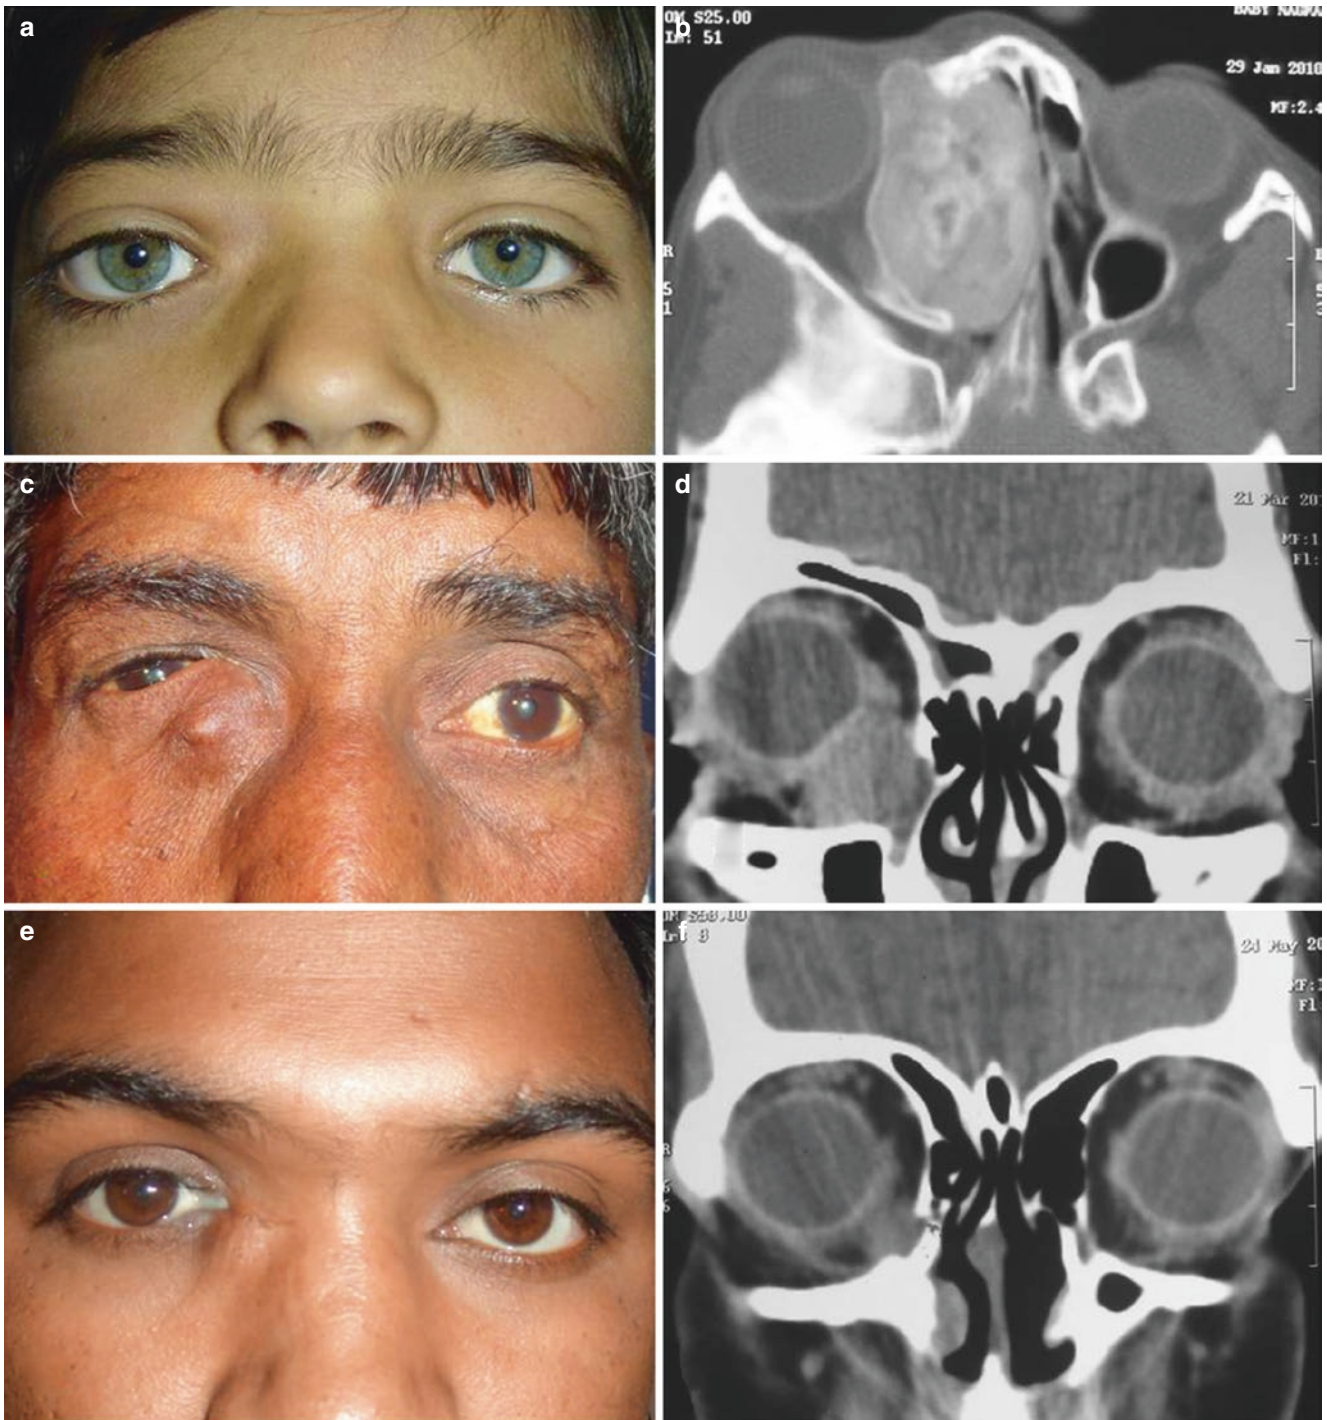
Imaging findings in patients with epiphora. Young child with unilateral telecanthus complaining of watering from right eye (a). CT scan revealed an ethmoid sinus mass (fibrous dysplasia) extending to nasal cavity causing secondary NLD obstruction (b). Adult patient with distended lacrimal sac and partially patent irrigation (c). CT scan
